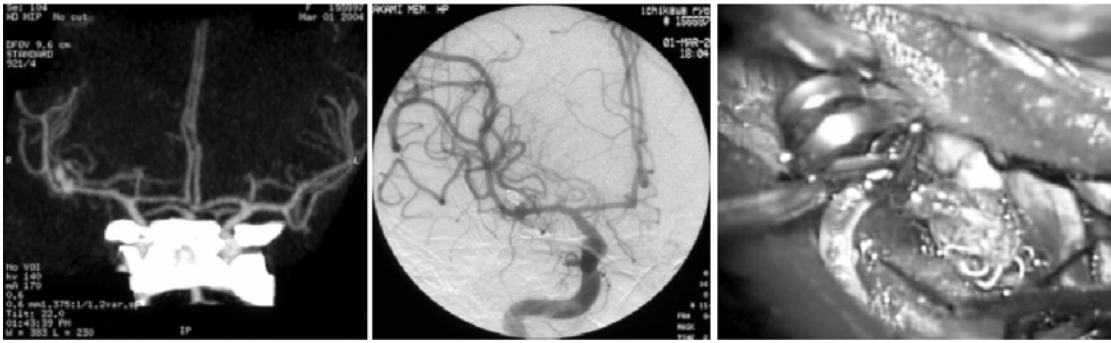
Left:* 3D CT angiogram shows a ruptured right MCA aneurysm with ill-defined neck and mild vasospasm adjacent to the aneurysm. *Center:* Right carotid angiogram obtained after tentative coil embolization demonstrates that the rupture site of aneurysm was occluded with aneurysmal neck patent. *Right:* Definitive neck clipping was performed without difficulty
